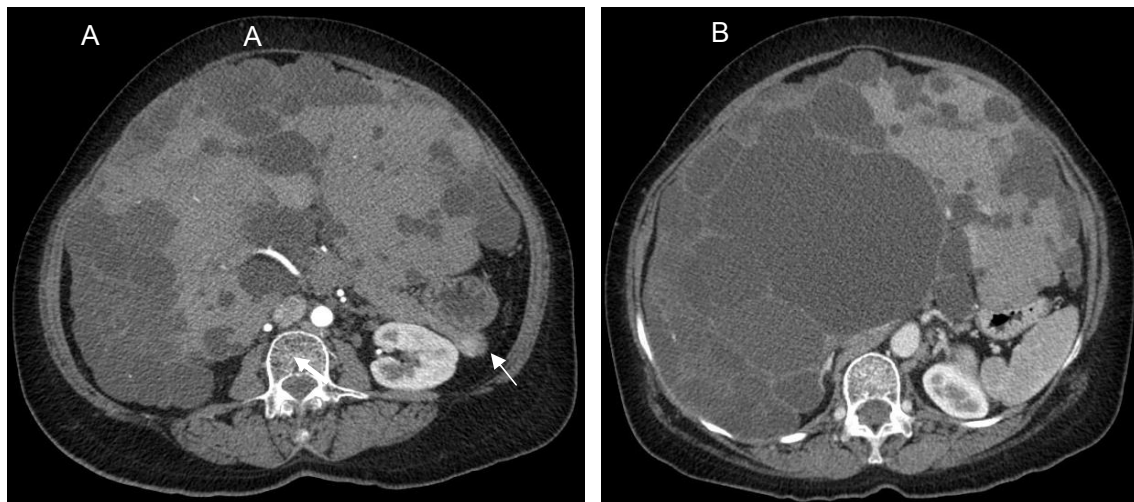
CT scan of the pancreas. A. Arterial phase showing a lesion with contrast reinforcement (arrow). B. Venous phase showing polycystic liver disease
